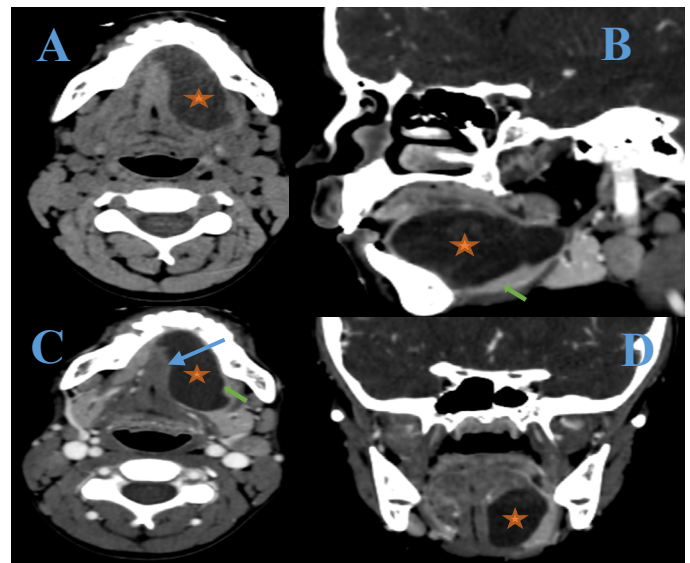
Head and neck CT scan in spontaneous and after contrast injection, in axial (A, C) sections, with coronal (D) and sagittal (B) reconstructions: Oblong cystic formation in the floor of the mouth, lateralized to the left, with hypodense fluid content (star) and enhanced wall after contrast administration, dissects the fascial planes in the sublingual space around the mylohyoid muscle (blue arrow) and displaces the sublingual gland (green arrow).
